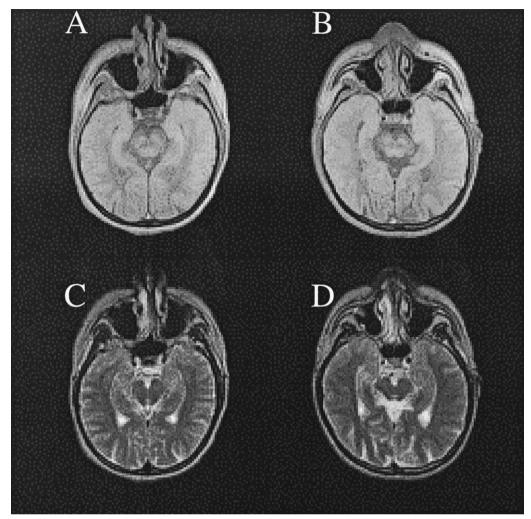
Examples of MR images in a control subject (first echo A; tenth echo C) and an epileptic patient with right hippocampal sclerosis (first echo B; tenth echo D).
